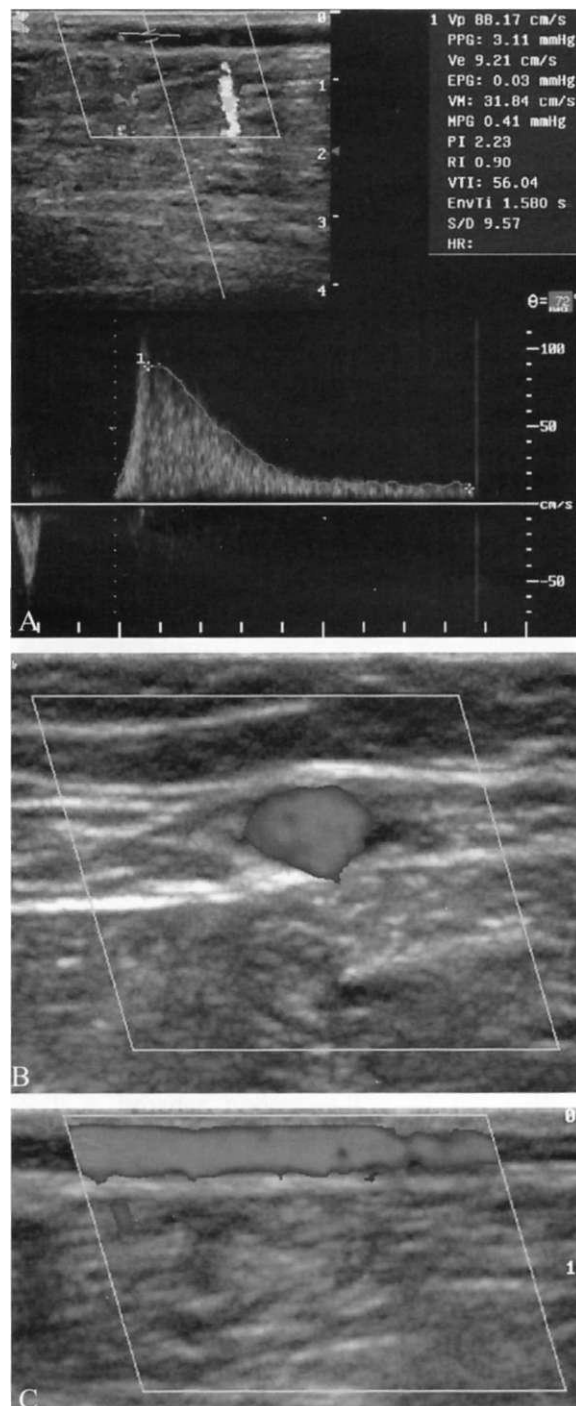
Doppler ultrasonography (A) and scans in the transverse (B) and longitudinal (C) projections of the right GSV in the lower third of the thigh at the evening after the day orthostatic load in a patient aged 36 years. The intercuspular reflux lasted for 1.8 s and extended by 13 cm. The cross-section diameter of the GSV was 6.0 mm.
